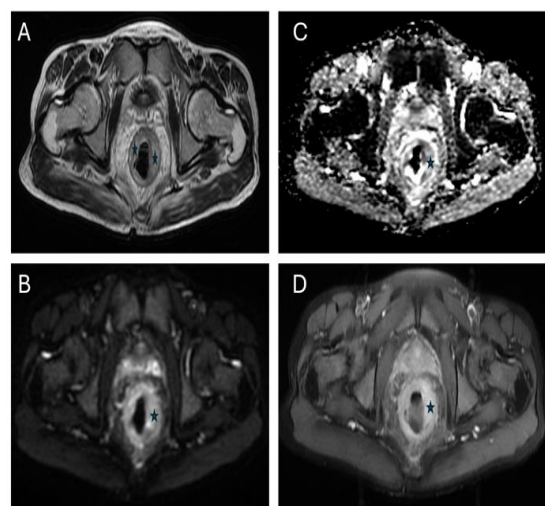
Ca rectum (*) - shows hyperintense signal on T2W images (A). (B) DWI images reveal high signal with low signal on ADC map (C) . Image (D) shows homogenous post contrast enhancement.
